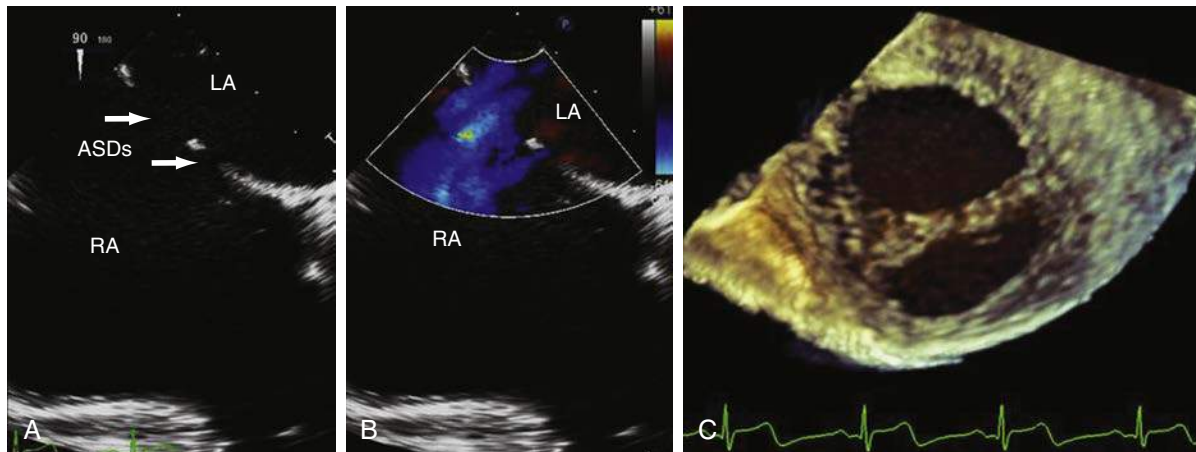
A, Two-dimensional transesophageal echocardiogram (2D TEE) at 90 degrees shows two secundum ASDs—a larger one posteriorly (*upper white arrow*) and a smaller one anteriorly (*lower white arrow*). B, Color Doppler shows the two separate flow jets through the ASDs. C, 3D TEE clearly shows the two separate ASDs. ASD, Atrial septal defect; LA, left atrium; RA, right atrium.
